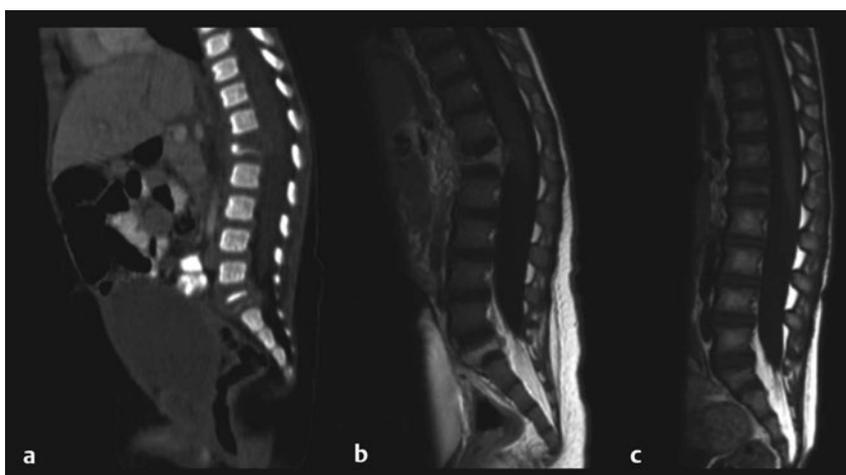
At the age of 9 months, this infant boy presented with weight loss and a palpable skull mass. Biopsy confirmed Langerhans cell histiocytosis. (a) Computed tomographic scan with sagittal reconstruction. Lytic lesions of L1 and S1 are seen. Note the kyphotic deformity. (b) Magnetic resonance (MR) image with gadolinium. Vertebra plana with an associated enhancing epidural component. (c) Follow-up sagittal MR image after chemotherapy and bracing. There has been partial reconstitution of the vertebral bodies, and the degree of kyphosis has diminished.
